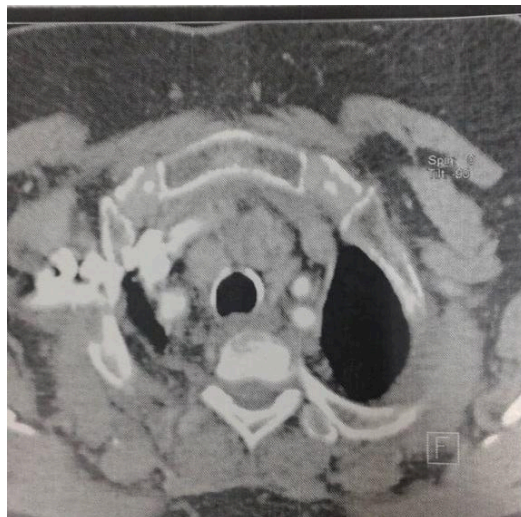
Axial CT scan showing the 2nd mediastinal mass
